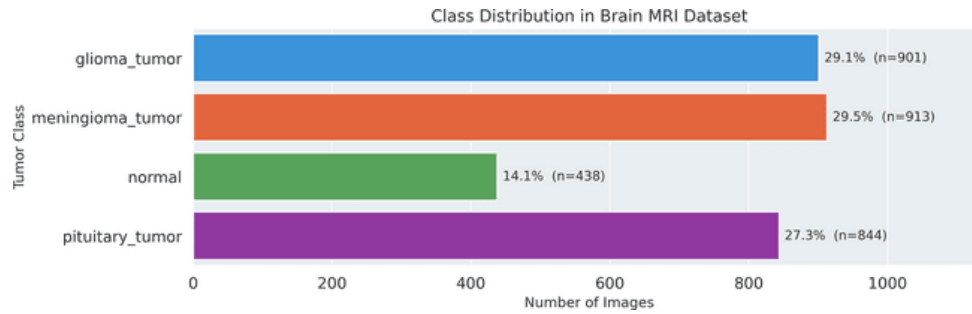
Class distribution of the Daneshmand Brain MRI dataset. Meningioma is most represented (29.5%) and normal least represented (14.1%), yielding an imbalance ratio of  $2.08 \times$ .
